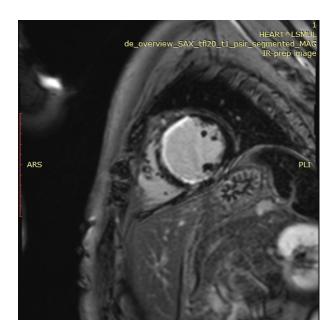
Cardiac magnetic resonance imaging: short-axis view demonstrates delayed subendocardial enhancement of the anterior and inferior left ventricle walls and interventricular septum.
